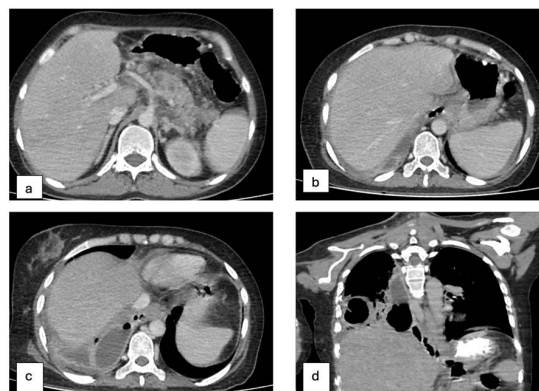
a, b, c- Axial and d- coronal contrast enhanced CT abdomen images showing walled of necrosis with pancreaticopleural fistula (Arrow) with the right pleural cavity
